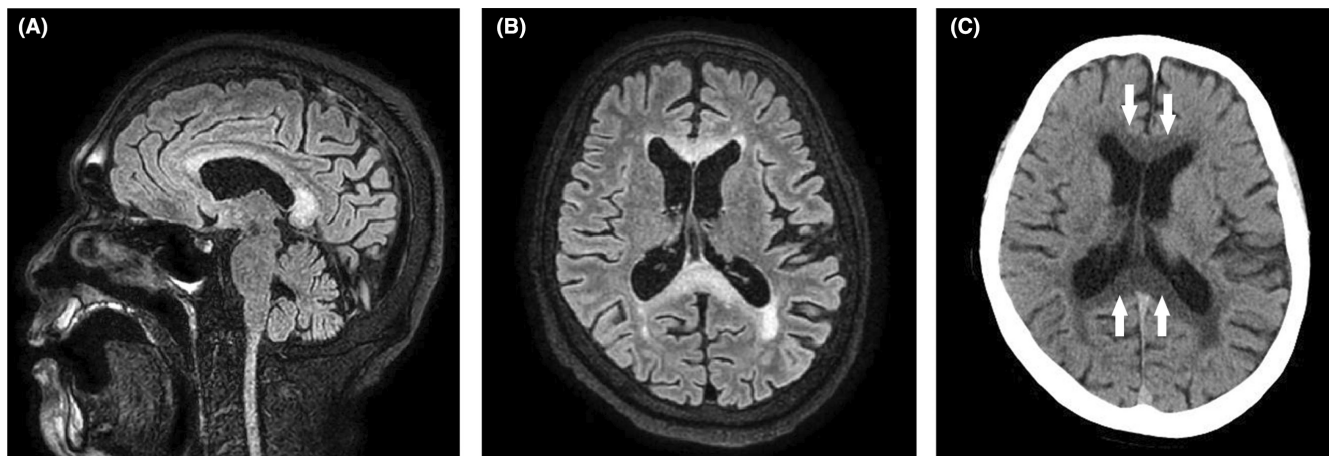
Patient MRI and CT findings. Sagittal (A) and axial (B) FLAIR images showing areas of hyperintensity throughout the corpus callosum. (C) Axial head CT images showing corpus callosum hypodensity (arrowhead)
